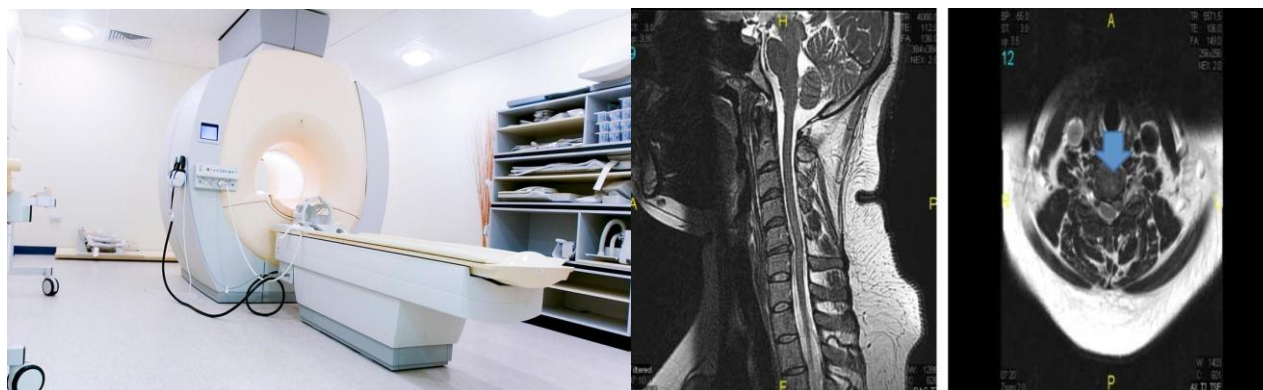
MRI of Cervical spine.
